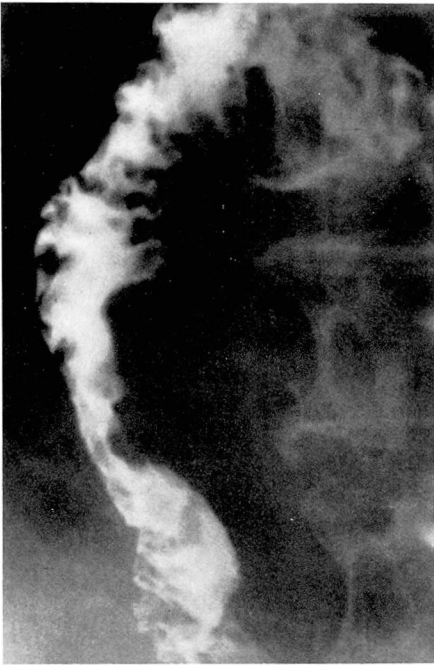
Roentgenogram showing involvement of medial duodenal wall by tumor.
